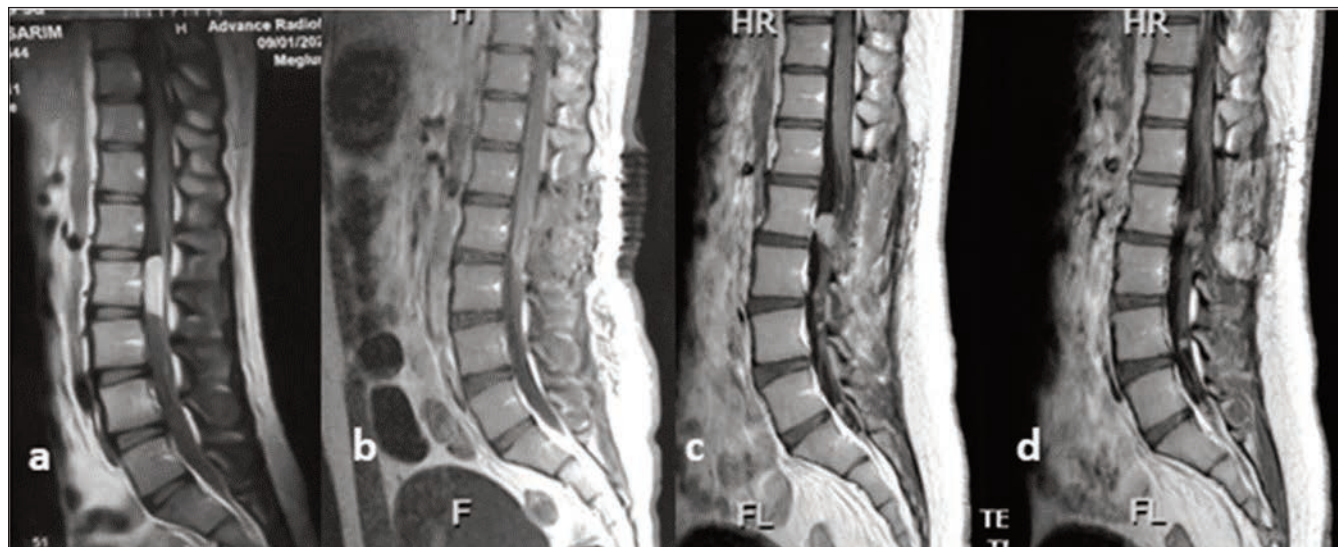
a shows preoperative sagittal T1 post contrast lumbar spine MRI displaying intradural enhancing lesion at L2. b shows the postoperative MRI with complete excision of ependymoma grade 2. c and d show multiple drop metastases at L2, L3 and L4, largest two at L2, four years later.
